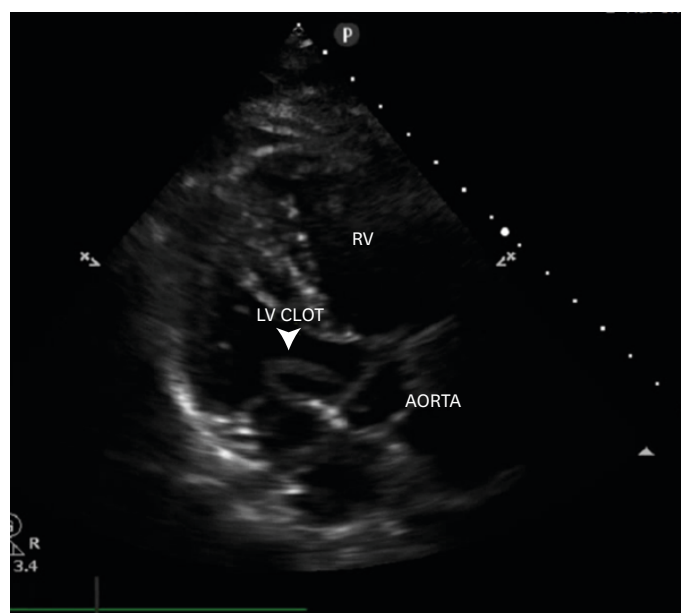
Parasternal long axis view showing a LV clot that protruded into the aorta. LV: left ventricle, RV: right ventricle.
